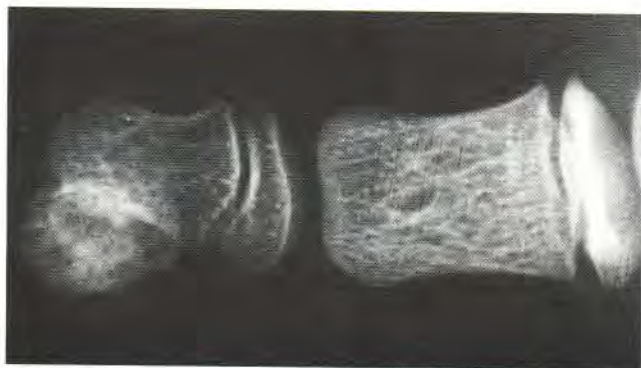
Radiograph showing the soft tissue calcified mass.
